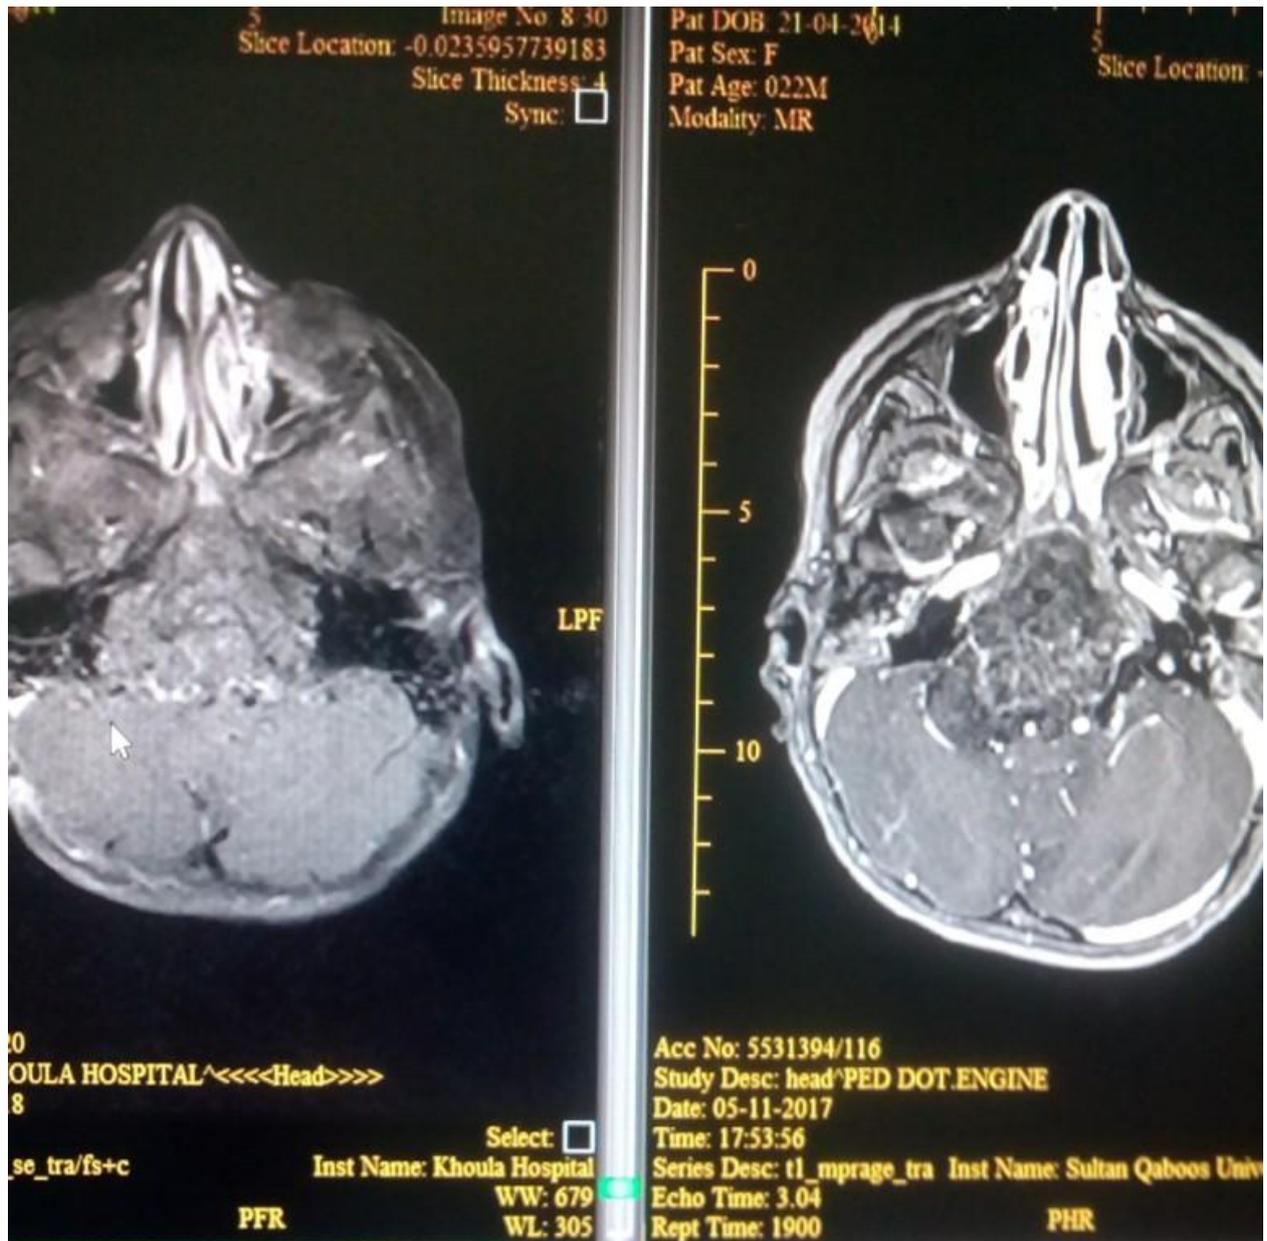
Pre and post op MRI of the patient
